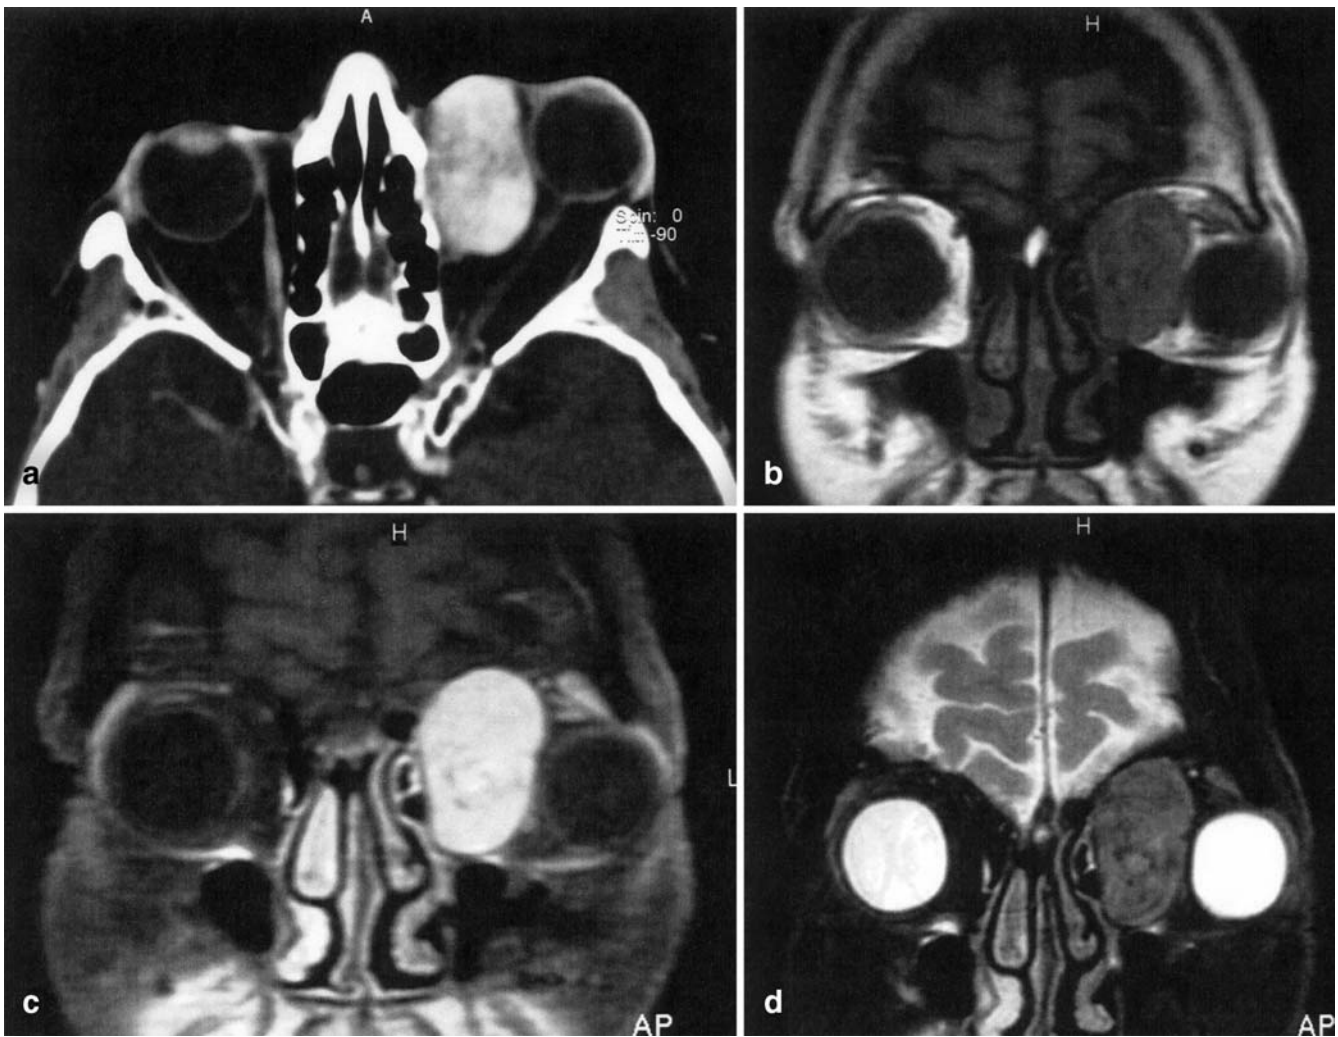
Solitary fibrous tumor of left medial orbit. A markedly enhancing well-defined ovoid lesion is visible stretching the optic nerve because of displacement of the globe antero-laterally (a). The left orbit appears slightly enlarged because of flattening and thickening of the medial orbital wall. The extraconal tumor location is delineated to better advantage on the coronal T1-weighted noncontrast MR image (b). Following contrast administration (c) the tumor shows marked signal intensity increase. On the T2-weighted coronal image (d), a hypointense (*dark*) signal is present reflecting the fibrous and cellular nature of the lesion
